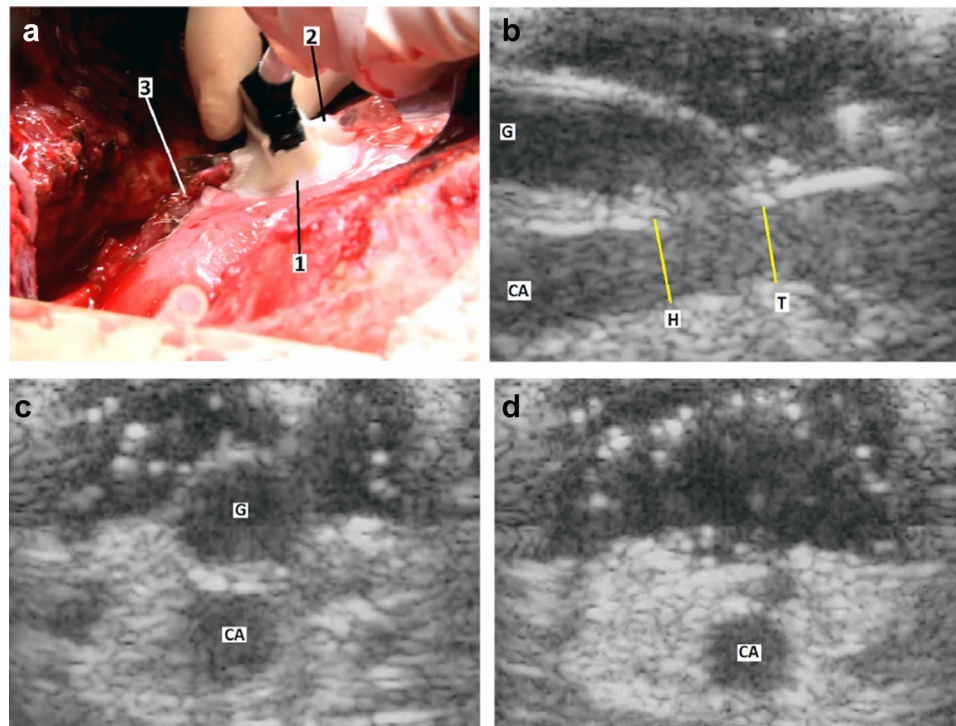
(a) Acquisition of epicardial ultrasound (EUS) sequences using an EchoClip (1) (Staalsen *et al.* 2011). The Echo-Clip contain a cavity (2) for the ultrasound gel to maintain acoustic contact of the anastomosis without deforming the graft (3). (b) A longitudinal plane of an end-to-side anastomosis obtained using the EchoClip (G = bypass graft, CA = coronary artery). The *yellow lines* represent the heel (H) and toe (T) sites of the anastomosis. These sites mark the endpoints of the middle section of the anastomosis. Distal to heel and toe sites are the heel and toe sections of the anastomosis. These sections can be used to obtain a reference vessel area of the native coronary artery to determine the stenotic rates of heel and toe sites. (c) Cross-sectional image of the heel site corresponding to the *yellow line* on the left in (b). (d) Cross-sectional image of the toe site corresponding to the *yellow line* on the right in (b).
